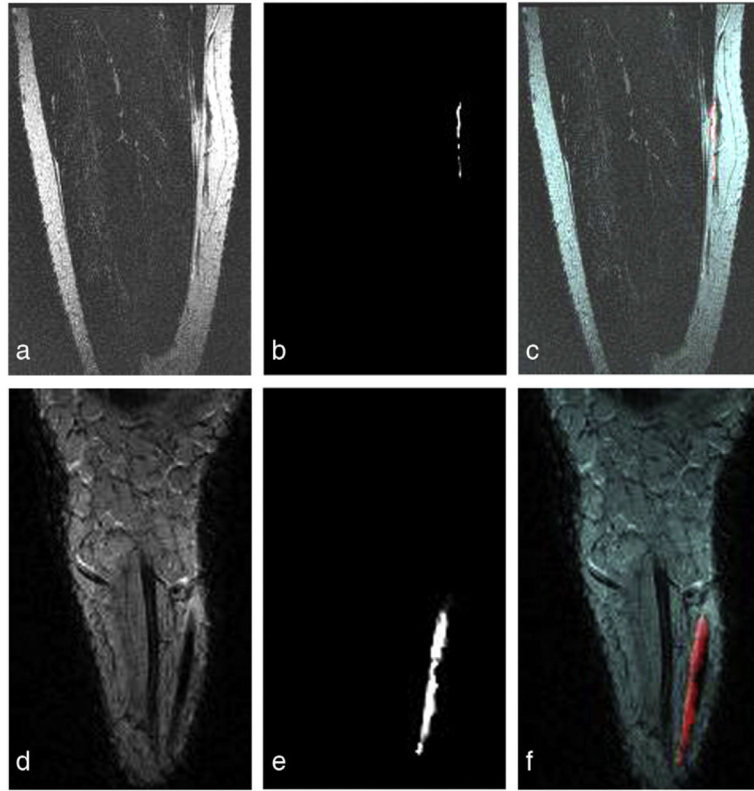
Oblique coronal T₂-weighted MRIs and the co-registered FA maps computed from 32-direction DTI data from two different subjects: Top images (a–c) are from the same subject as shown in this figure, in which the acquired coronal slice is in the orientation as defined using three different slice locations of the axial images as indicated in (a). The figure depicts (a and d) anatomical T₂-weighted MRIs, (b and e) registered FA maps, and (c and f) the superposition of each FA map (red hue) to each subject's anatomical coronal T₂-weighted MRI showing that the FA map follows the anatomically confirmed sural nerve structure.
